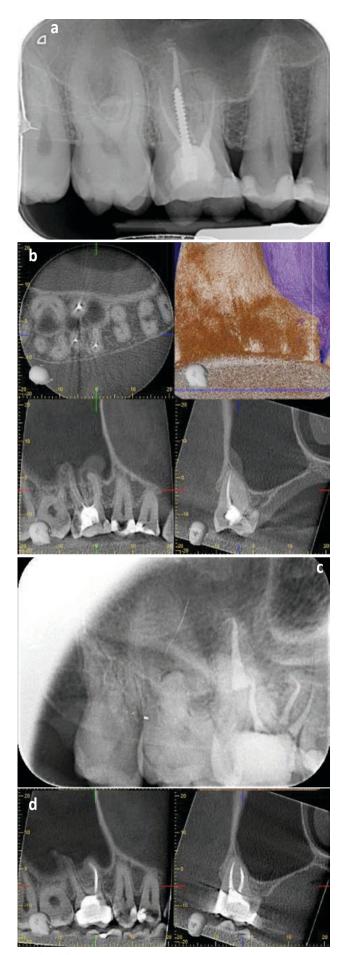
a - preoperative radiograph; b - preoperative CBCT; c - postoperative radiograph; d- follow-up CBCT
